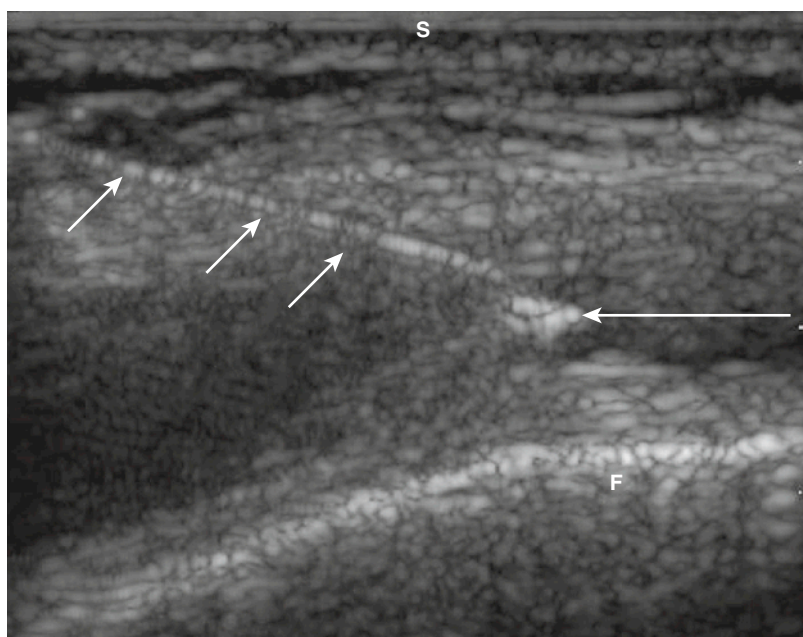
In ultrasound-guided injection of the bursa, the shaft (*short arrows*) and the tip of the needle are visible. The tip is located within the fluid-filled iliotibial bursa (*long arrow*). The needle is parallel to the long axis of the transducer. F, femur; S, skin.
